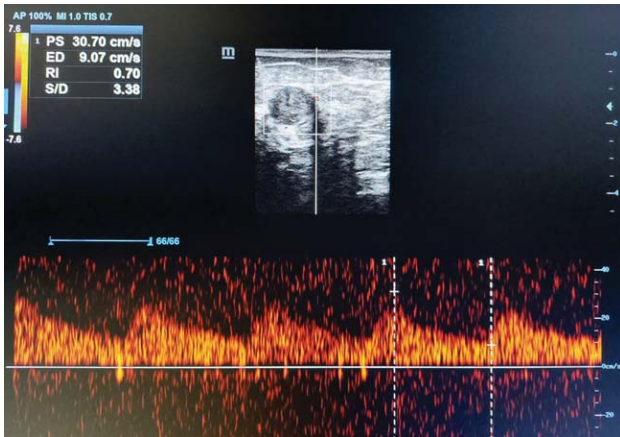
Doppler ultrasound of a breast lesion showing RI values of 0.7 suggesting a benign looking lesion.
